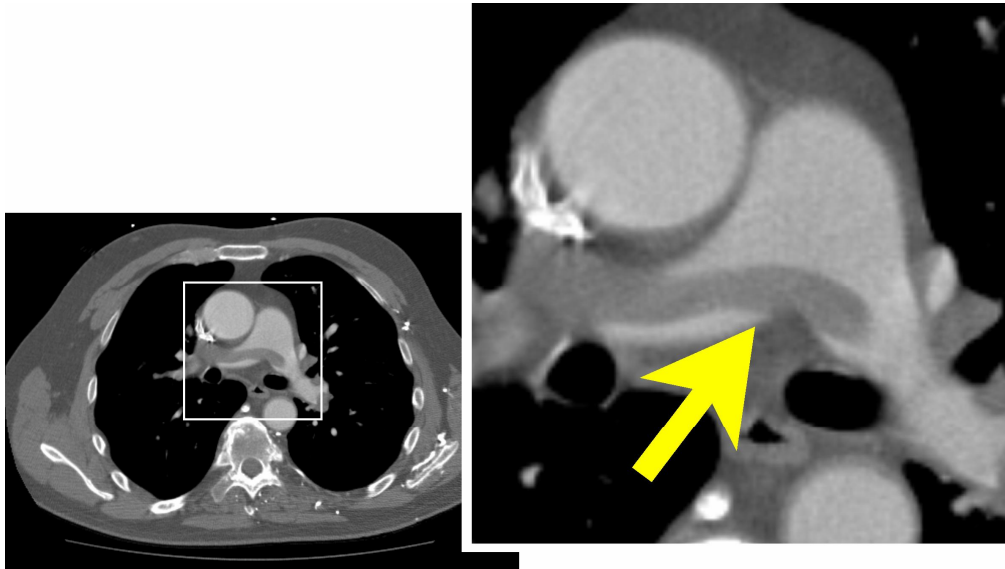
CTA axial slice showing a pulmonary embolus (dark spot) inside the pulmonary trunk (bright structure).
